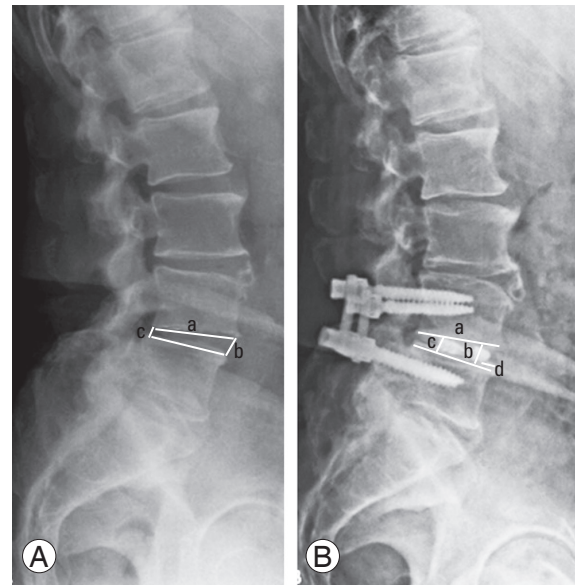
(A) Preoperative and (B) postoperative lateral radiographs demonstrating measurements used. (A) Preoperative measurements include (a) segmental lordosis, (b) anterior disc height, and (c) posterior disc height. (B) Postoperative measurements include (a) segmental lordosis, (b) anterior disc height, (c) posterior disc height, and (d) anteroposterior cage position.
